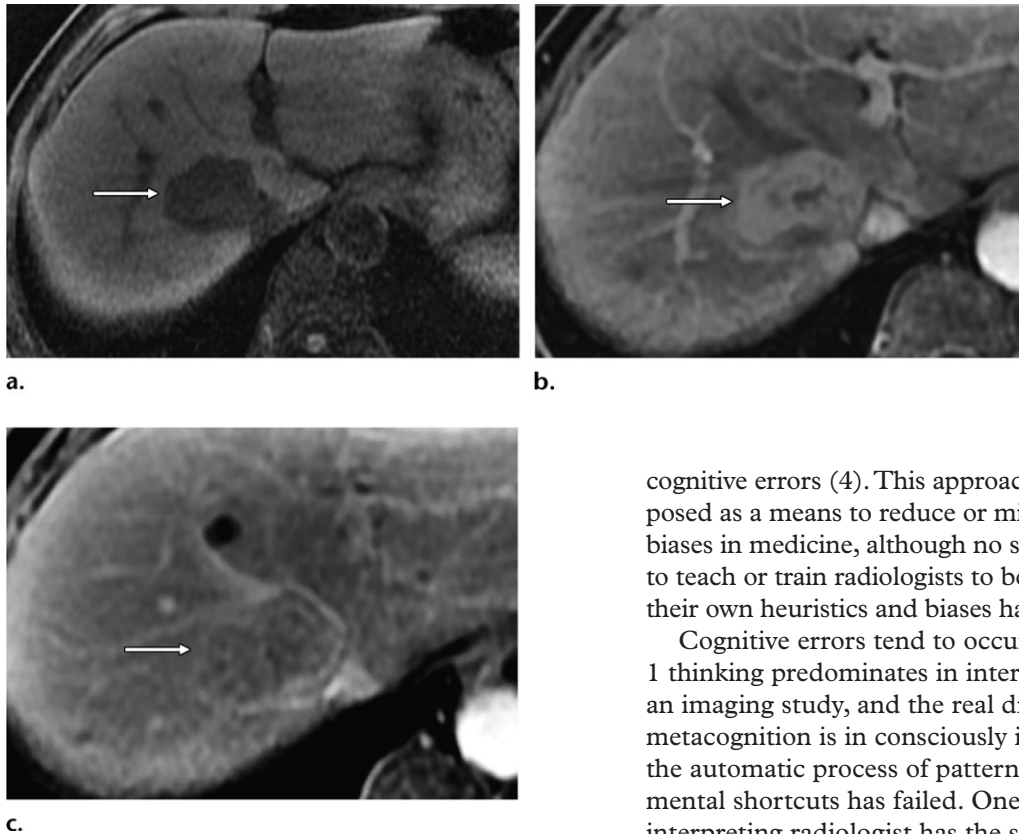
HCC in a 67-year-old woman with hepatitis C and a liver mass who underwent MRI of the abdomen at an outside institution. The indication on the outside report was “hepatocellular carcinoma.” The outside report impression read “enhancing liver lesion demonstrates enhancement pattern and signal morphology, which is commonly seen with FNH.” The study was reinterpreted at our institution, with our impression reading “a 4.0 cm lesion with constellation of findings favoring focal nodular hyperplasia.” (a) Axial T1-weighted image shows a lesion (arrow) with signal intensity atypical for FNH and most consistent with HCC. (b) Contrast-enhanced image shows arterial enhancement of the lesion (arrow), which can be seen in both FNH and HCC. (c) On an equilibrium phase image, the lesion shows washout and a pseudocapsule (arrow), which are diagnostic of HCC in the setting of cirrhosis. Biopsy demonstrated HCC. The radiologist reinterpreting the study was influenced by the original radiologist’s report, representing an alliterative error.
